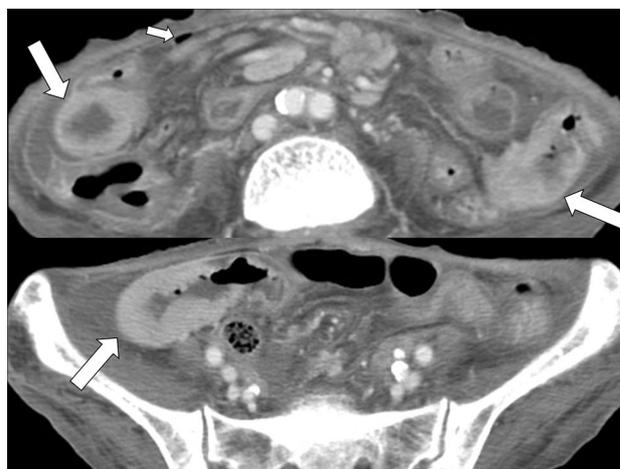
A 78-year-old woman presenting with acute abdominal pain. Enhanced CT images show multifocal, enhanced wall thickening of the jejunum and proximal ileum (arrows). In addition, note free air (small arrow, upper), peritoneal fat strandings, peritoneal thickening, and fluid collections, indicating perforation with peritonitis. This was confirmed as peripheral T-cell lymphoma
